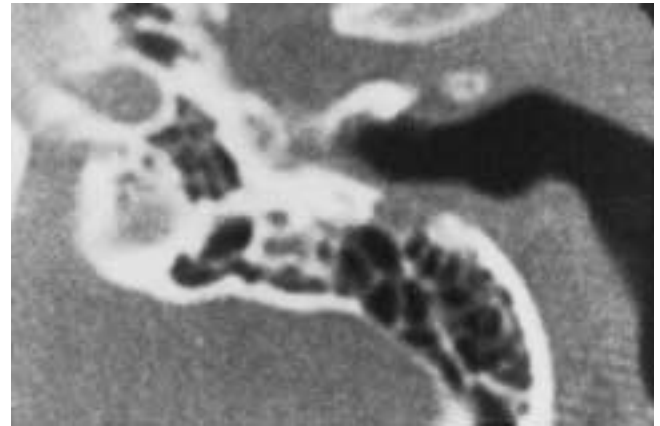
Early EAC squamous cell carcinoma. CT. Note the ill-defined localized cortical destruction on the posterior wall of the bony EAC. (Compare with Figs. 25-105 and 25-110.)
